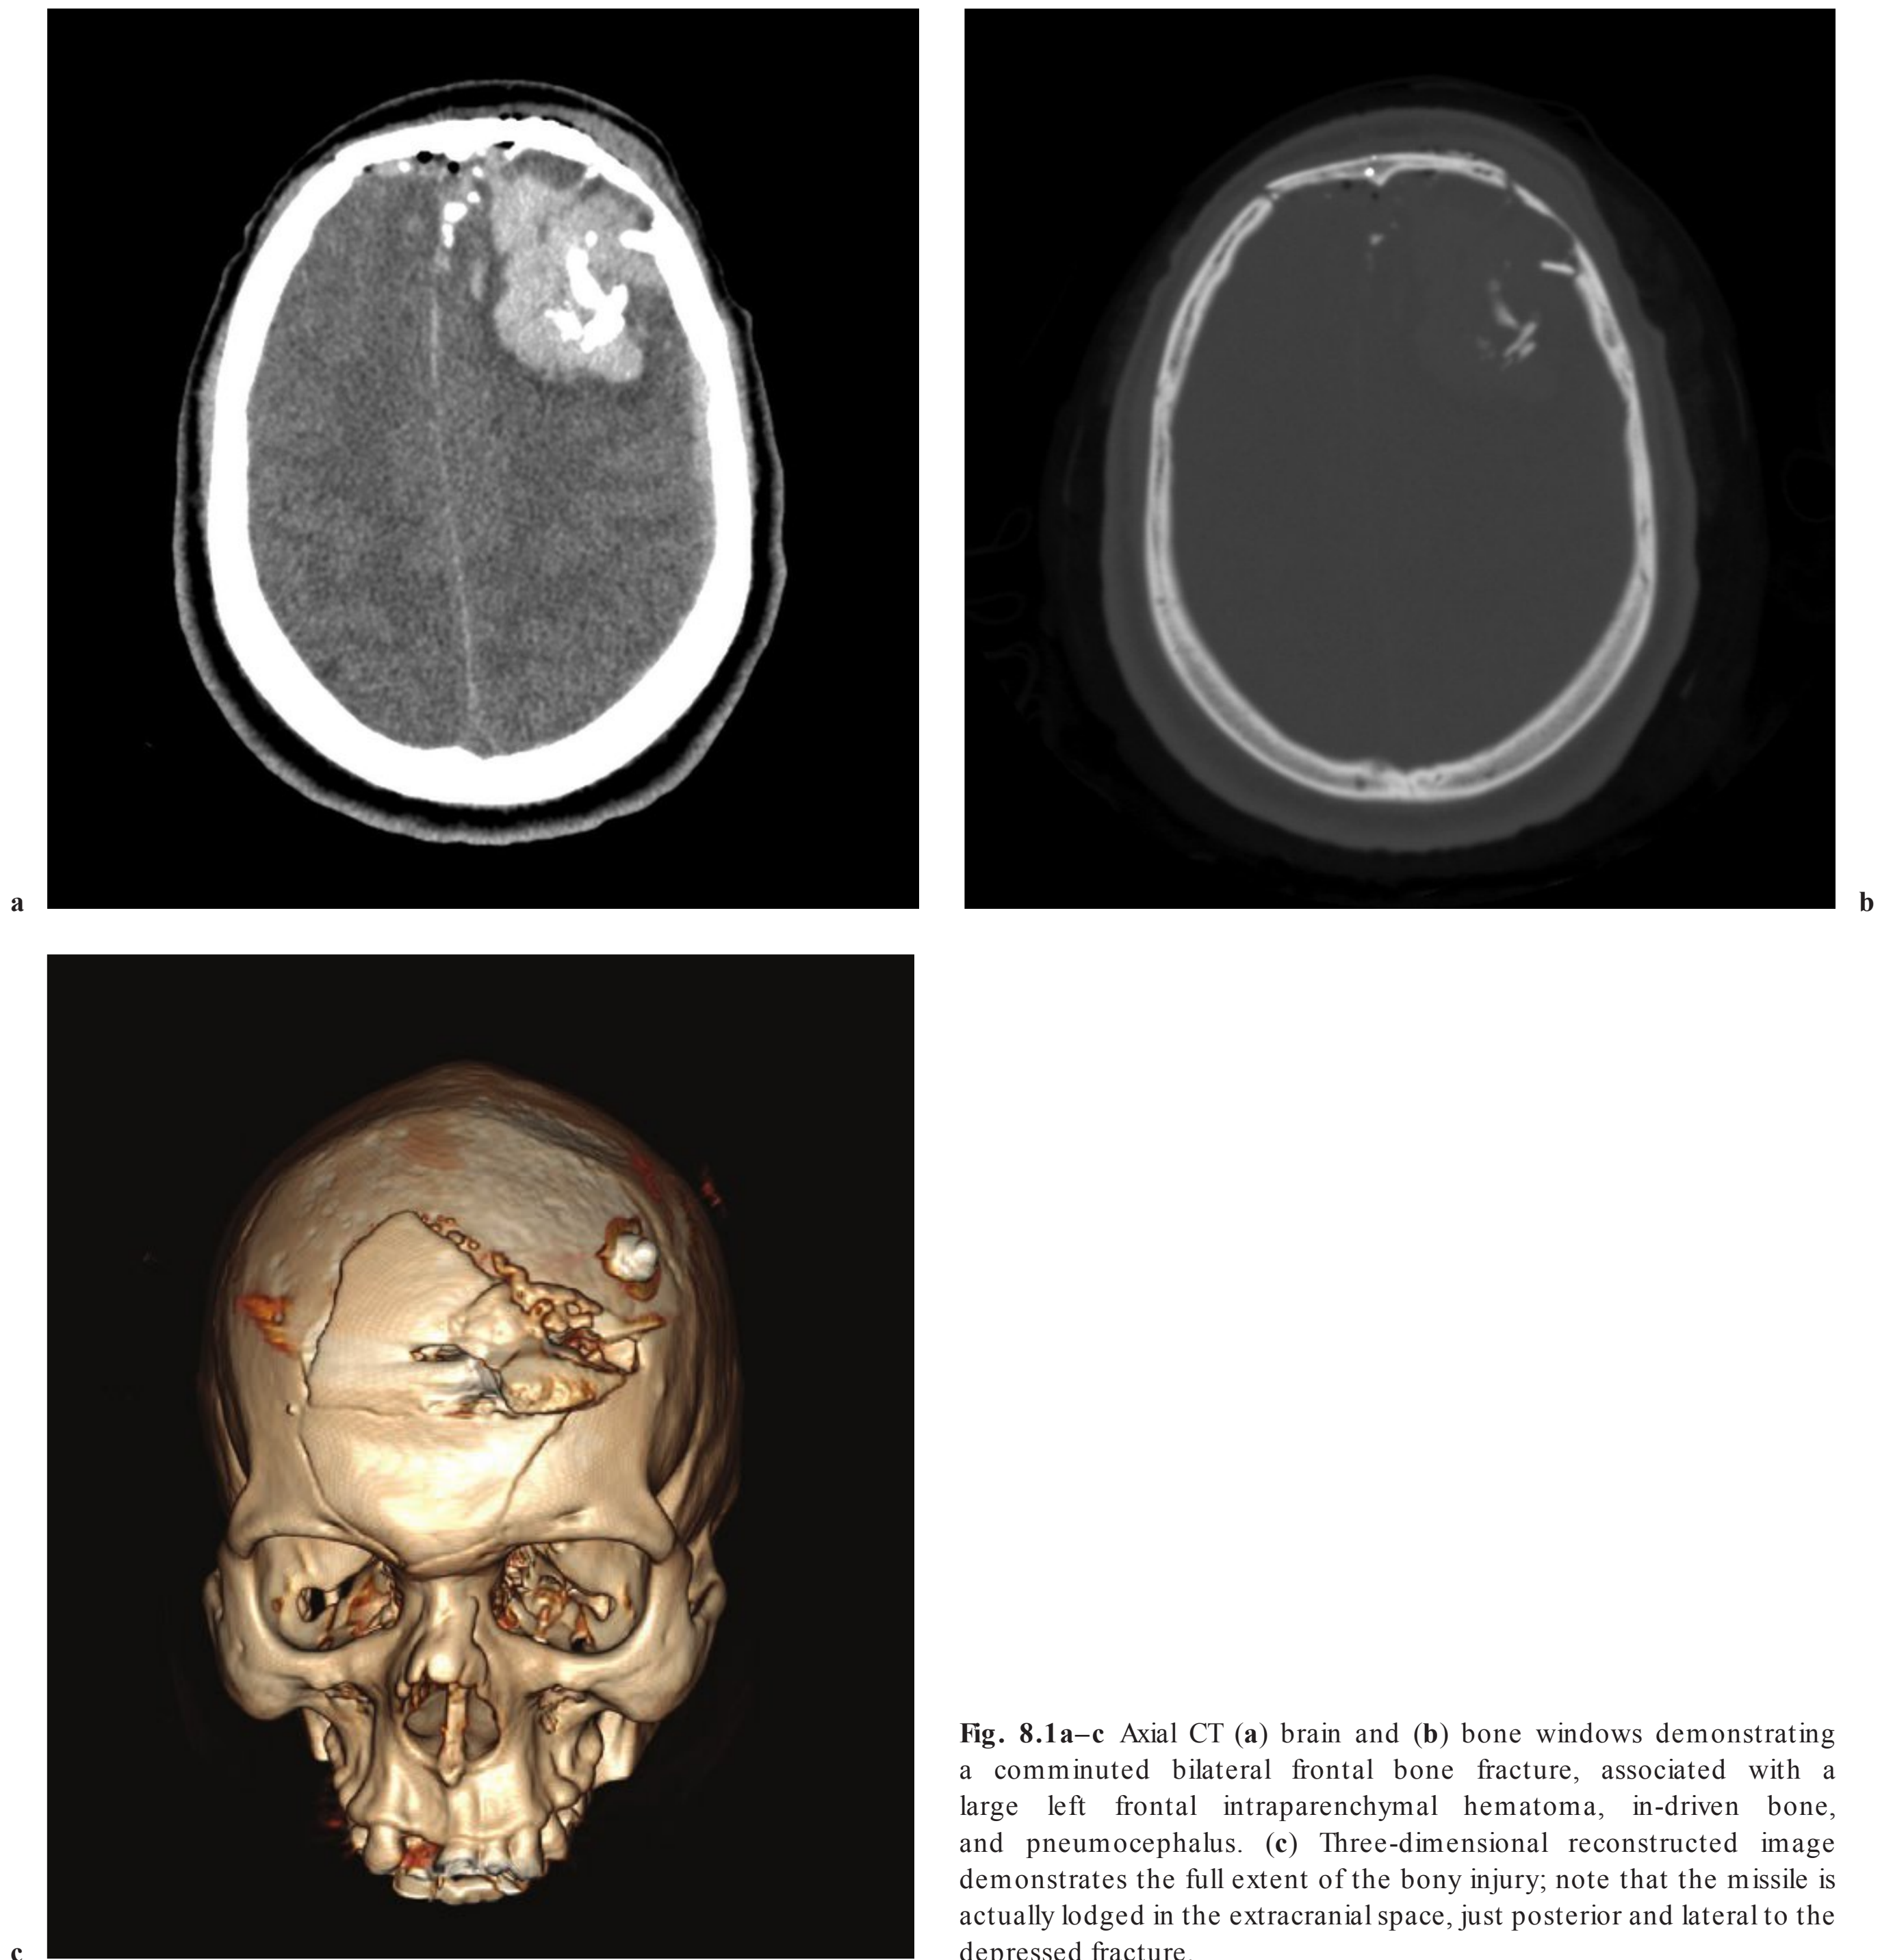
Axial CT (a) brain and (b) bone windows demonstrating a comminuted bilateral frontal bone fracture, associated with a large left frontal intraparenchymal hematoma, in-driven bone, and pneumocephalus. (c) Three-dimensional reconstructed image demonstrates the full extent of the bony injury; note that the missile is actually lodged in the extracranial space, just posterior and lateral to the depressed fracture.
